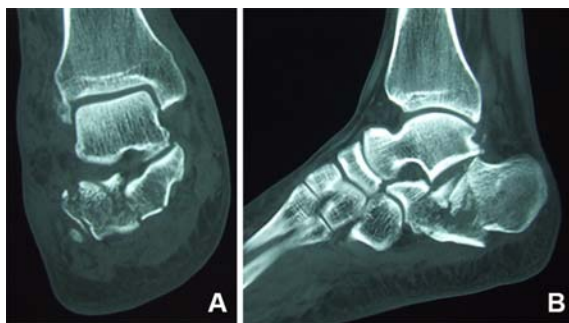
Computed tomography (CT) images of intra-articular calcaneal fracture (A: semi-coronal view; B: sagittal view).
